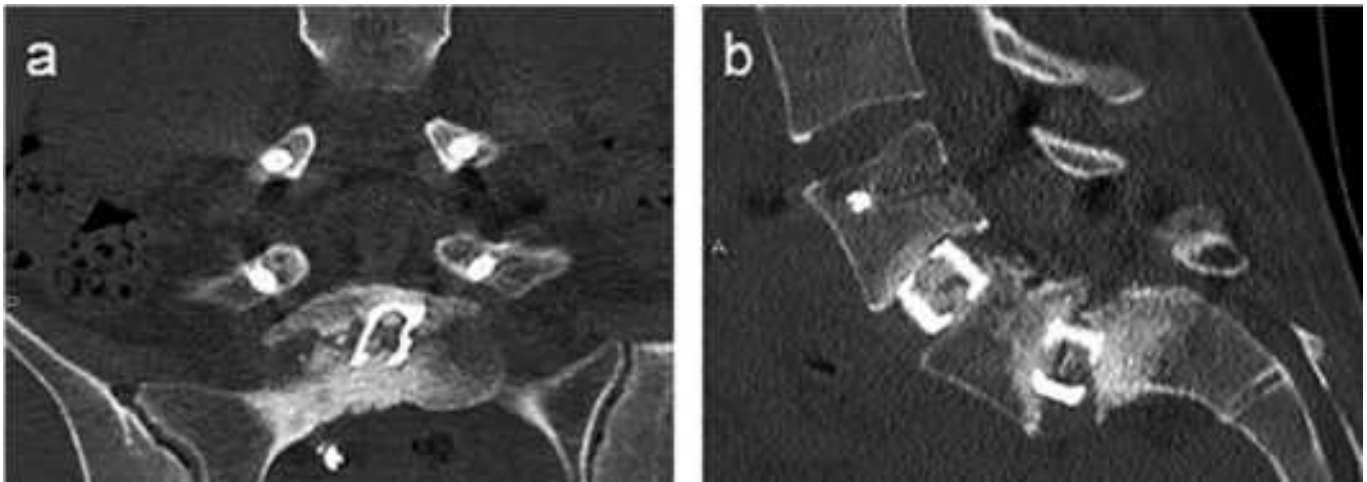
Computed tomographic scans of the subject with non-union at L5/S1. a) Coronal and b) sagittal computed tomographic scans showing non-union at L5/S1, 1 year after surgery.
